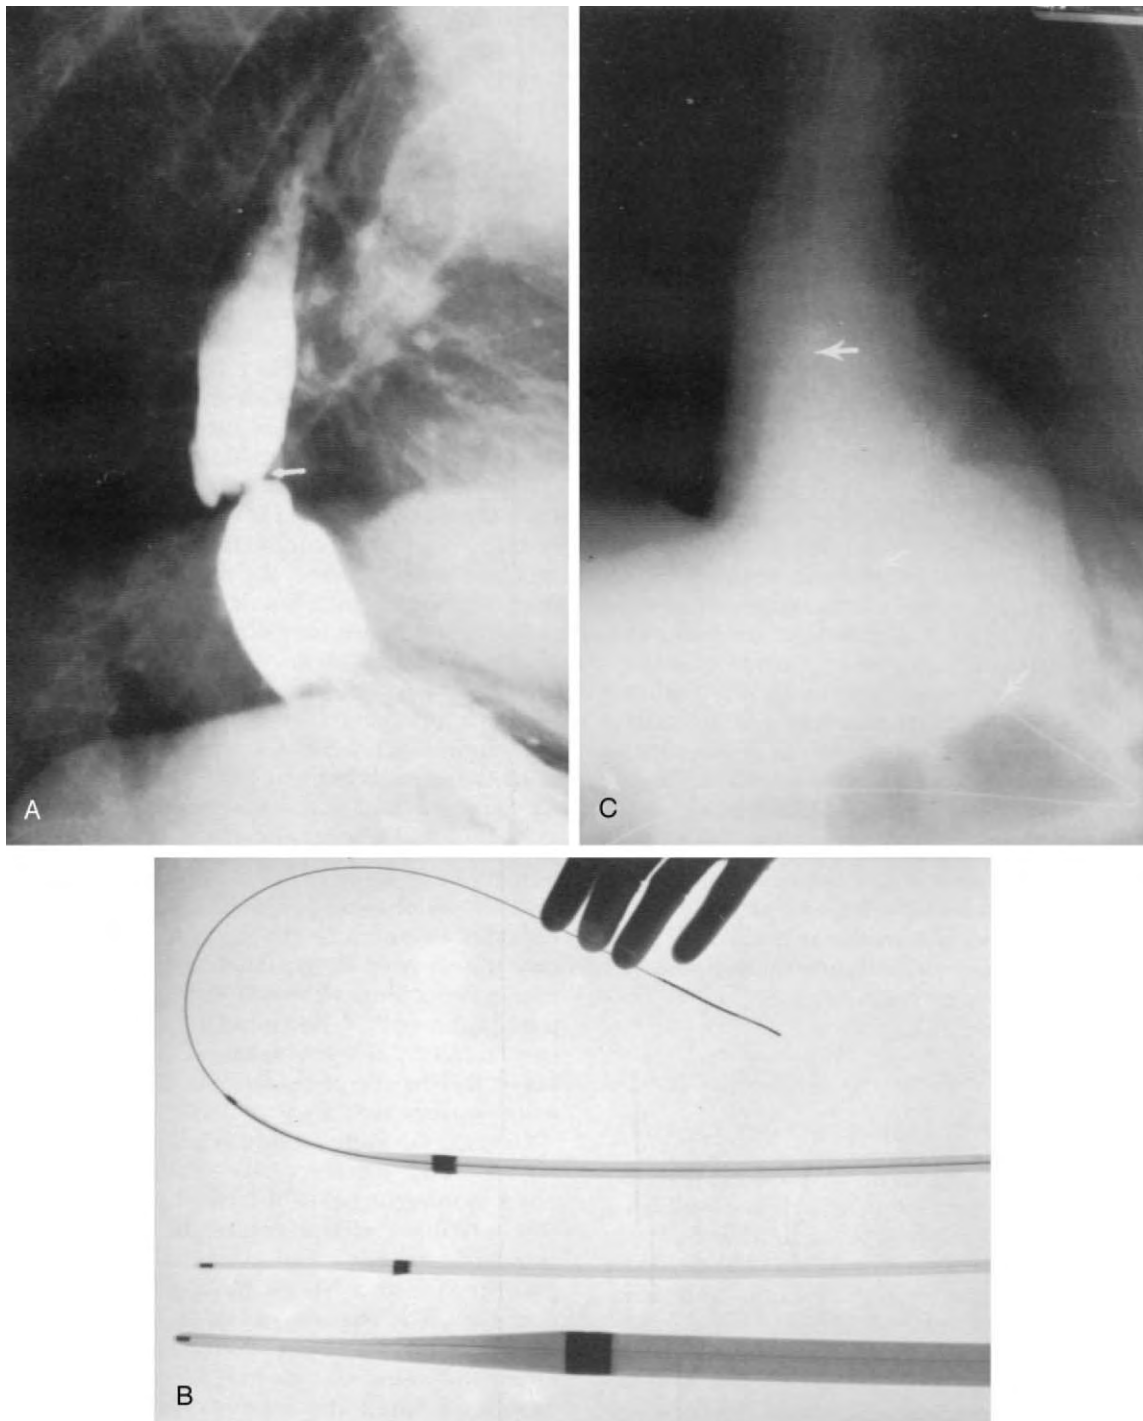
A, Esophagogram showing an eccentric complex reflux stricture (*arrow*) at the esophagogastric junction proximal to a large sliding hiatal hernia. Because of the diverticulum-like configuration of the lumen in the region of the stricture, blind passage of a Maloney bougie was thought to be unsafe. B, Several sizes of polyvinyl Savary-Gillard dilators with a guidewire passed through the upper dilator. C, Radiographic confirmation of the proper course of the endoscopically placed Savary guidewire (*arrow*) through the esophageal stenosis and into the stomach (same patient as shown in A). Progressively larger Savary dilators up to 54 French were passed over the wire and through the stricture. Blind passage of Maloney dilators on an outpatient basis was then achieved without difficulty. (From Orringer MB: Short esophagus and peptic stricture. In Sabiston DC Jr, Spencer FC [eds]: *Surgery of the Chest*, 6th ed. Philadelphia, WB Saunders, 1995, p 1060.)
